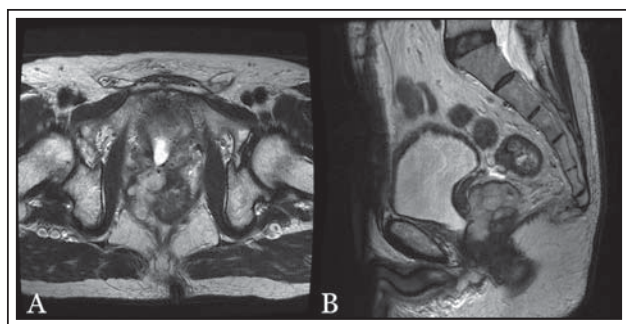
Magnetic resonance imaging (MRI) showing relationship between the prostatic lesion and the rectal wall; A. axial, B. sagittal.
